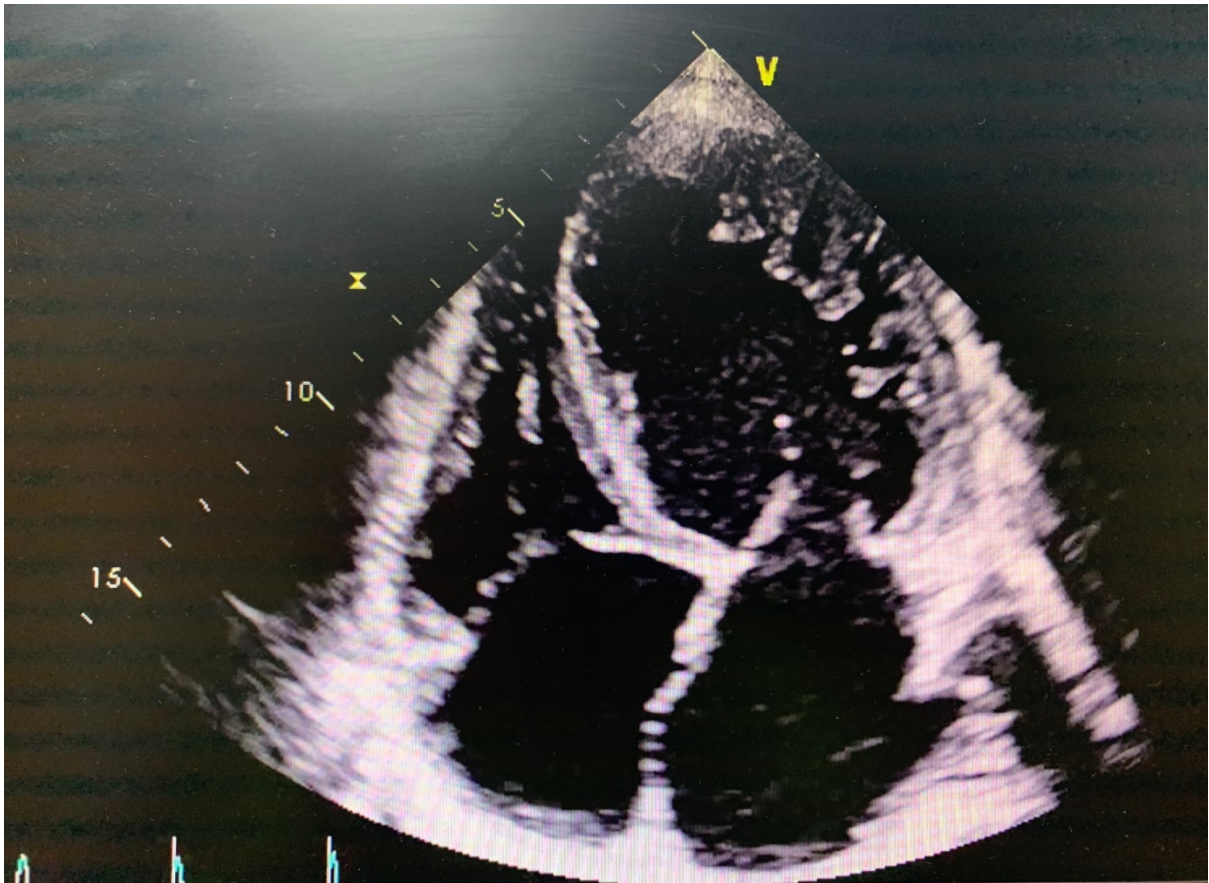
Four-chamber view on 2D transthoracic echocardiogram showing aneurysmal dilation of the left ventricular mid/apical segments, in end-diastole of cardiac cycle, patient was on Tacrolimus. Ejection fraction by Simpson's biplane method 11%.
